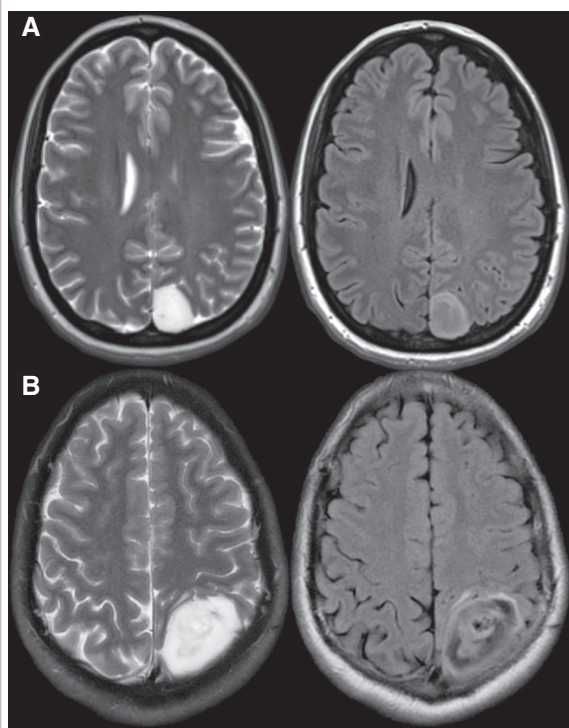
Two examples of the T2-FLAIR mismatch sign with axial T2-weighted imaging (left) and corresponding T2-FLAIR-weighted imaging (right). Example A was diagnosed as astrocytoma, IDH-mutant, WHO grade 2. Example B was diagnosed as astrocytoma, IDH-mutant, WHO grade 3. Cases courtesy of Dr. Evan Calabrese, Duke University Medical Center.
